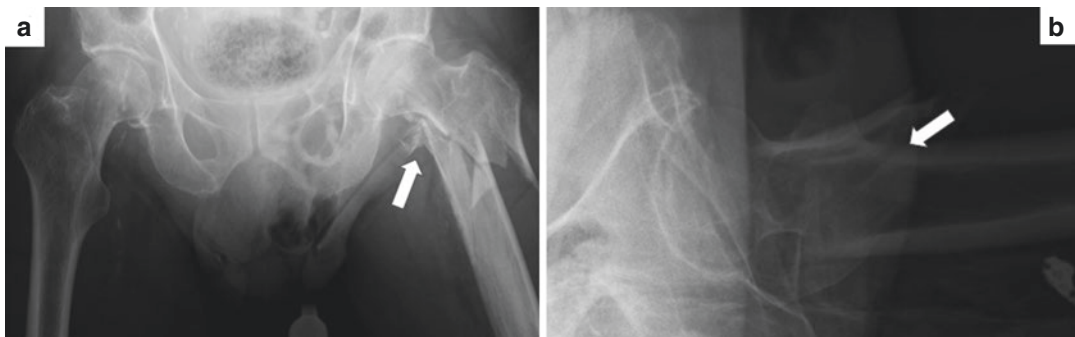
(a) AP pelvic radiograph and (b) lateral left hip showing (arrows) a reverse oblique fracture pattern
